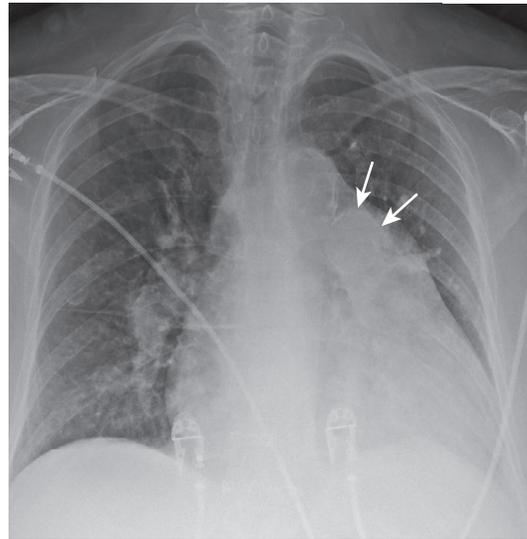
PA chest radiograph in a patient with congenital heart disease with pulmonary arterial hypertension. The calcified pulmonary artery (arrows) indicates that it has carried systemic pressure. The patient is now presenting with Eisenmenger's physiology and mild interstitial pulmonary edema. Note Kerley B lines in the base of the right lung.
